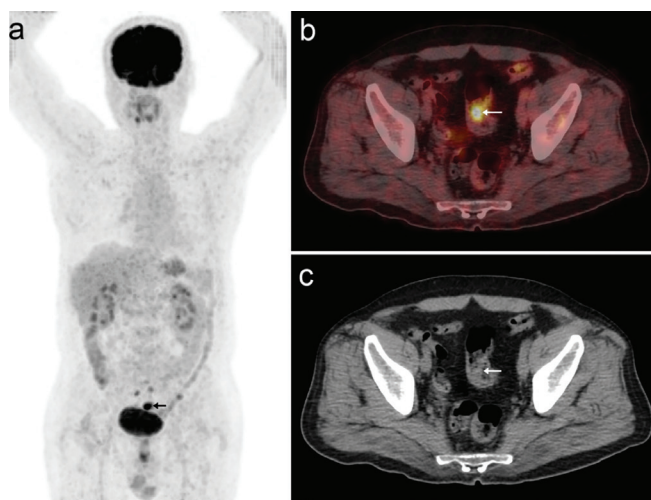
Representative example of incidental focal colorectal 18F-FDG uptake. Descriptions of Figure 1 are available in the Supplementary Material
